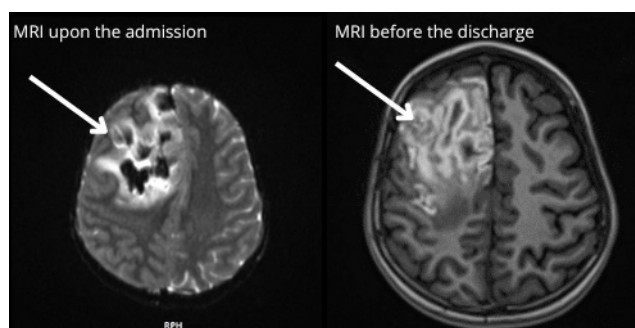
Comparison of the MRI scans upon the admission and a week before discharge from hospital
